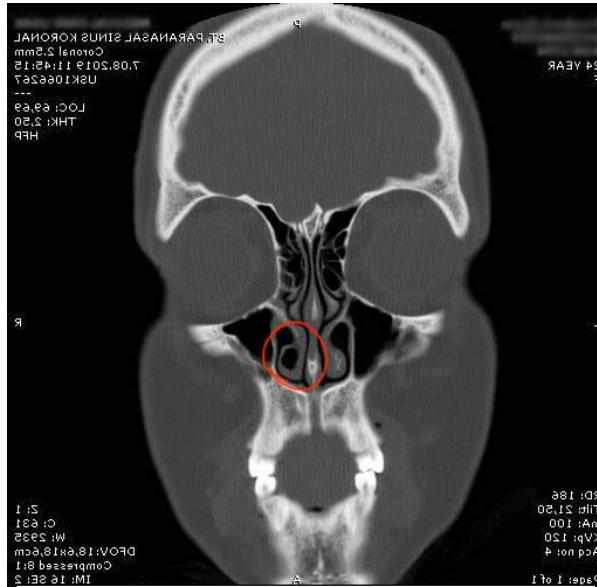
Paranasal sinus computed tomography image of the right inferior turbinate pneumatization. (Case 1, marked area)
